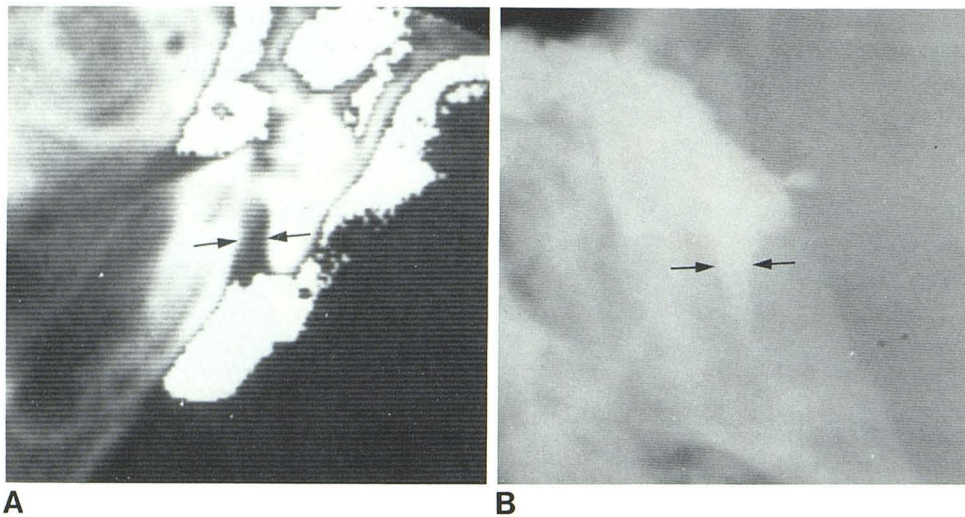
Case 4. A, CT gas cisternogram from positive-image scanner with range highlight facility. Nonfilling of internal auditory canal (arrows) with gas (shown in white). B, Pantopaque cisternogram. Normal filling of canal (arrows).
